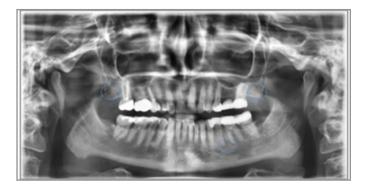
(a) Radiographic images taken before implant placement.
